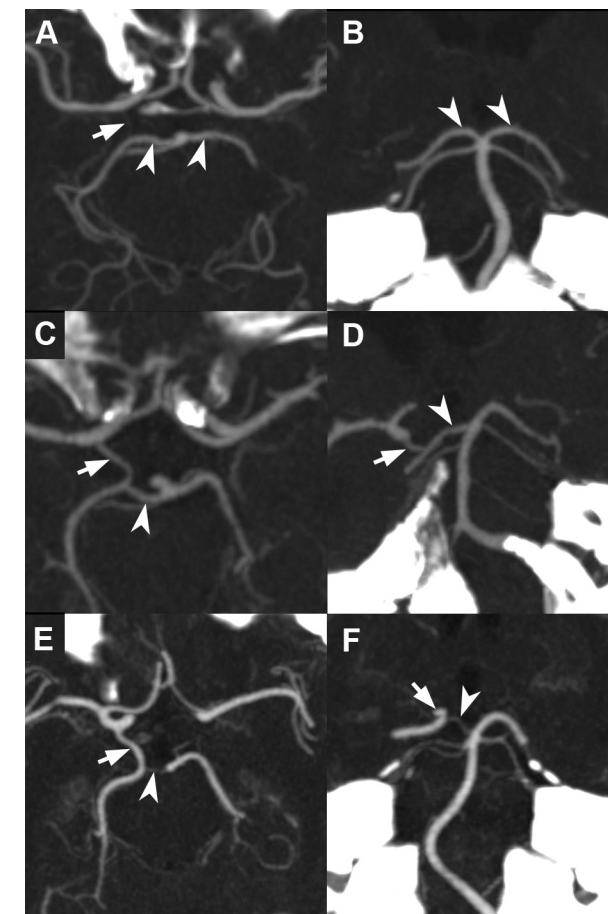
CT angiography of the circle of Willis. Maximum intensity projections (10mm) in an axial plane (a, c, e) and a plane parallel to the clivus (b, d, f).
